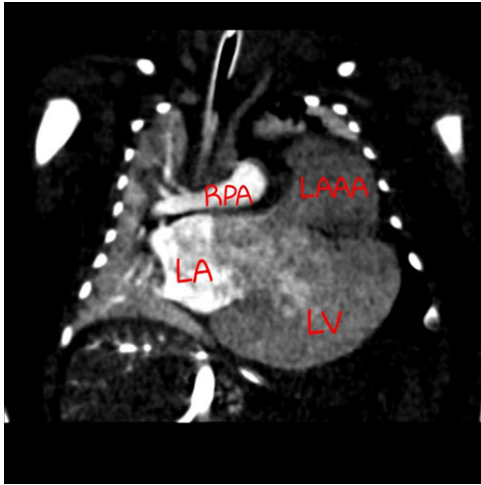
CT angiography image of LAAA for case 1. LA: left atrium; LV: left ventricle; RPA: Right pulmonary artery; LAAA: left atrial appendage aneurysm.
